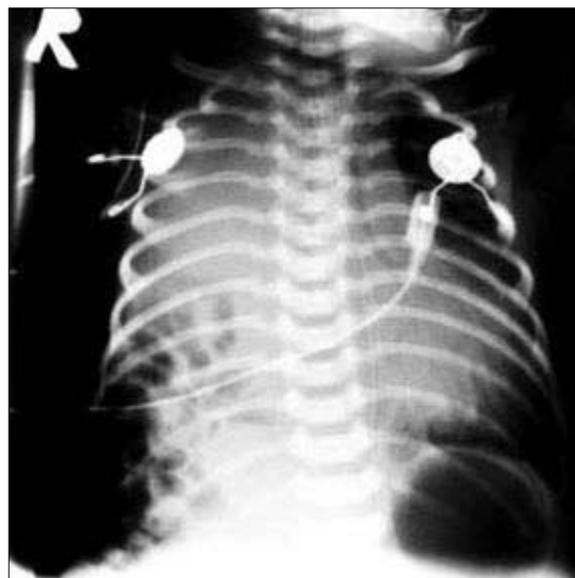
Anteroposterior chest x-ray of newborn at age of one day.
